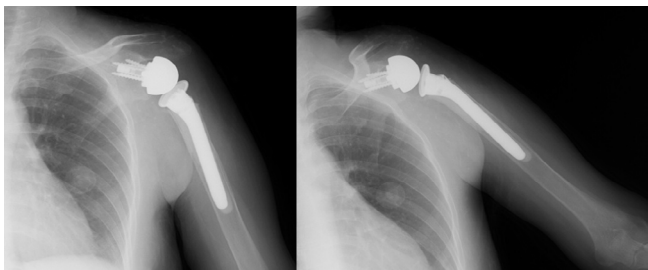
Radiographic view of shoulder prosthesis following the final surgical intervention.
